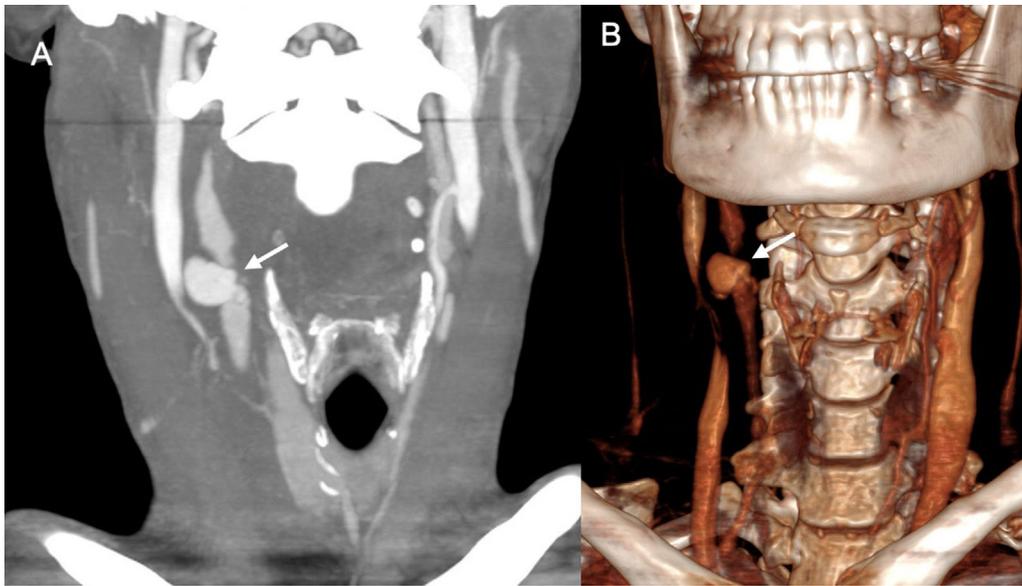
31-year-old woman who suffered an assault involving a penetrating stab wound with right submandibular entry and extensive accompanying bleeding requiring compression. Coronal maximum intensity projection (A) and 3D CT angiography reconstructions of the supra-aortic trunks in arterial phase showing a focal dilation of the right common carotid artery a few millimetres from its bifurcation, consistent with post-traumatic pseudoaneurysm.
